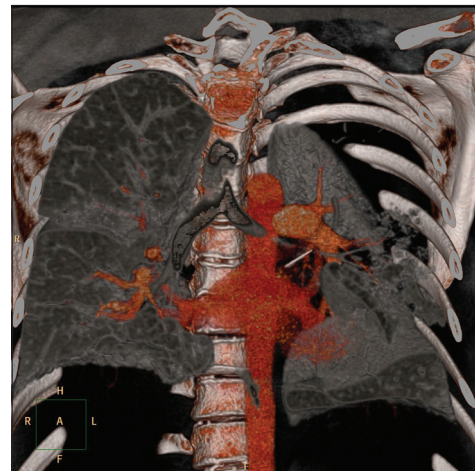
A reconstructed CT image of the same foreign body in the bronchus
